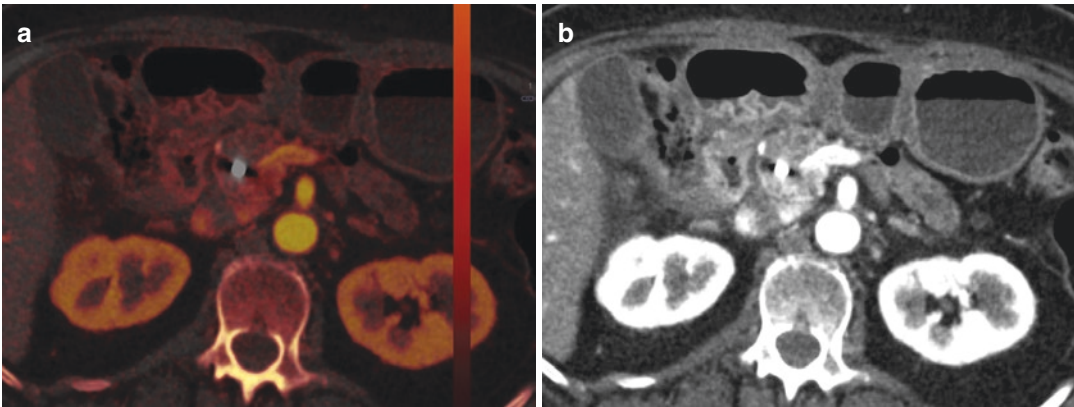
Iodine material attenuation map (a) post-processed axial CT scan demonstrates a pancreatic head carcinoma (a) which corresponds to the hypoattenuating
